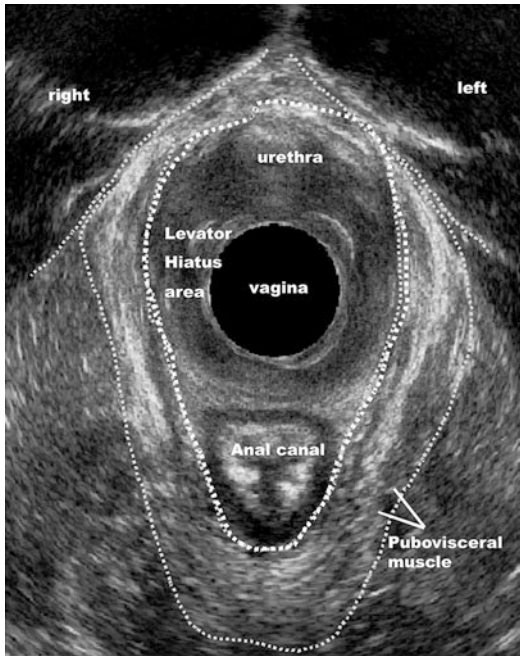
3D Endovaginal ultrasonography – the anatomic configuration of the pubovisceral muscle
